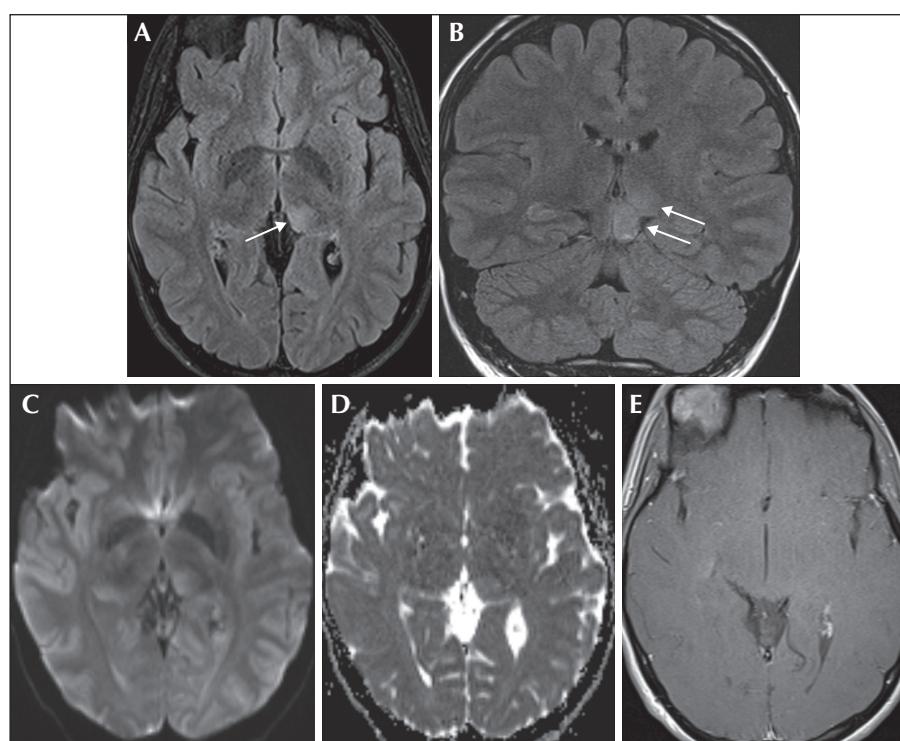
MRI images of the thalamic lesion. Axial (A) and coronal (B) T2-weighted fluid attenuated inversion recovery images show an infiltrative hyperintense lesion of the left thalamus and dorsal midbrain. Axial diffusion weighted (C) and apparent diffusion coefficient (D) sequences show facilitated diffusion. Axial T1-weighted post-gadolinium (E) shows no enhancement.
